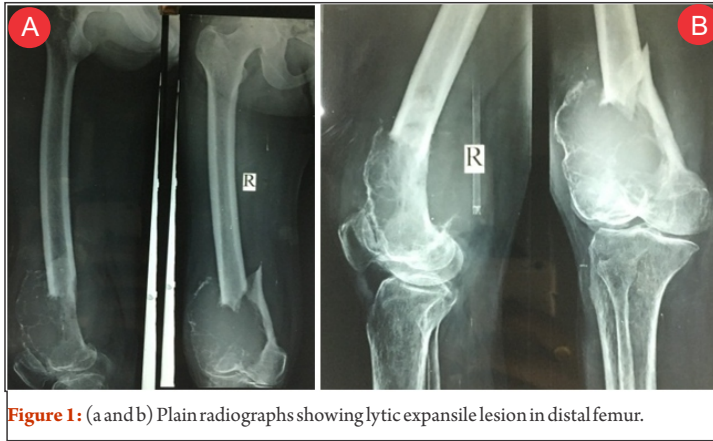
(a and b) Plain radiographs showing lytic expansile lesion in distal femur.
